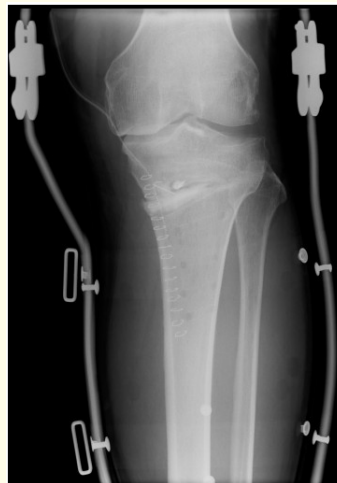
Postoperative X-ray image showing removed hardware without synthetic bone substitute.
